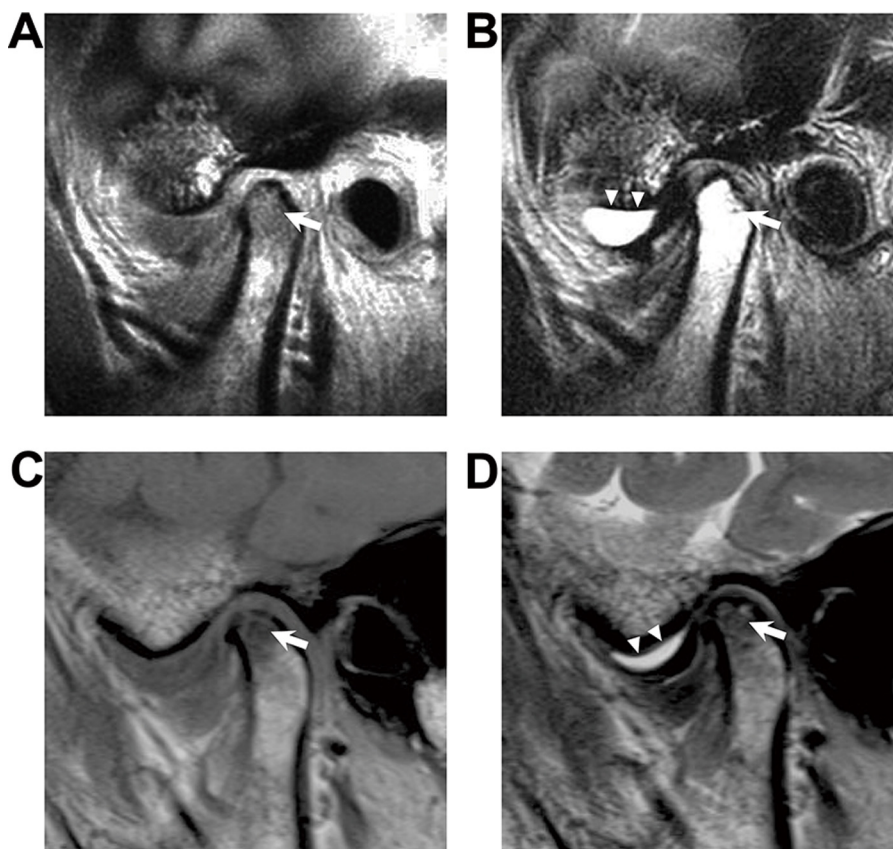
(A and B) Bone marrow edema pattern in the mandibular condyle. (A) Sagittal T1-weighted closed-mouth MR image shows an ill-defined area of abnormal decreased signal in the subchondral bone marrow (arrow). (B) Sagittal T2-weighted closed-mouth MR image demonstrates abnormal increased signal in the corresponding area (arrow) and effusion (arrowheads) in the superior joint space. (C and D) Bone marrow osteonecrosis pattern in the mandibular condyle. (C and D) Both sagittal T1-weighted and T2-weighted closed-mouth MR images show an ill-defined area of abnormal decreased signal in the mandibular bone marrow (arrow) and effusion (arrowheads) in the superior joint space.
